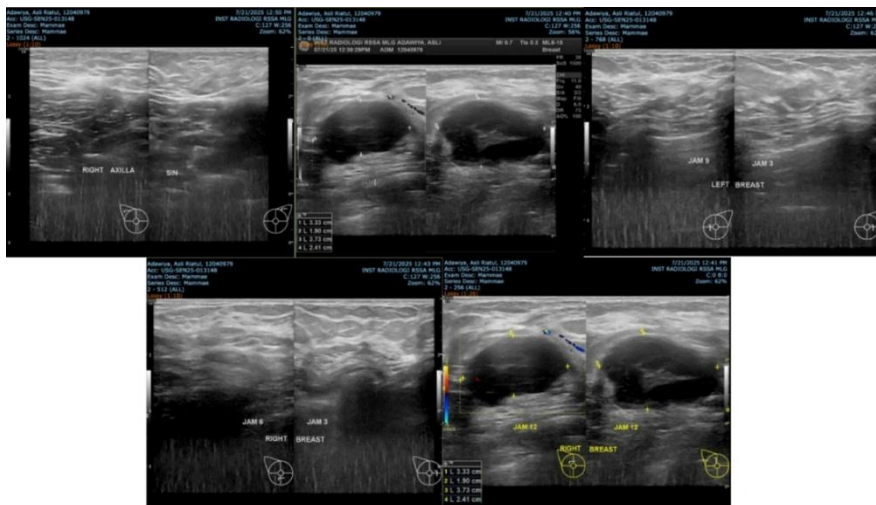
Breast ultrasonography showing a solid right breast mass, categorized as BI-RADS 4b, moderately suspicious for malignancy.
